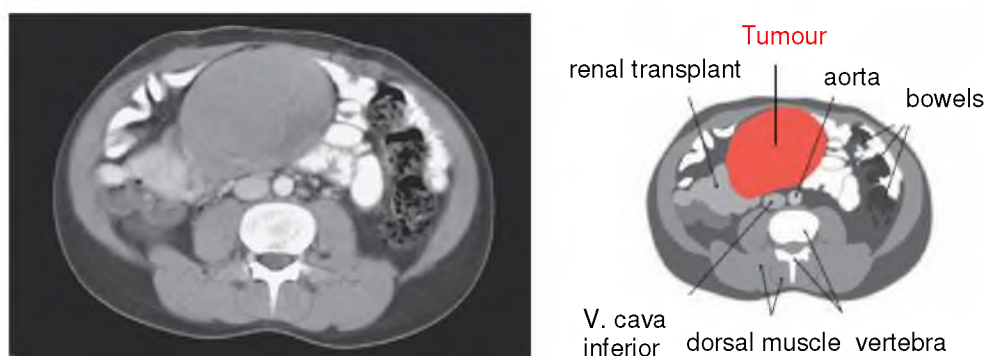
CT scan from patient A's abdomen showing a large dysgerminoma of the right ovary.
